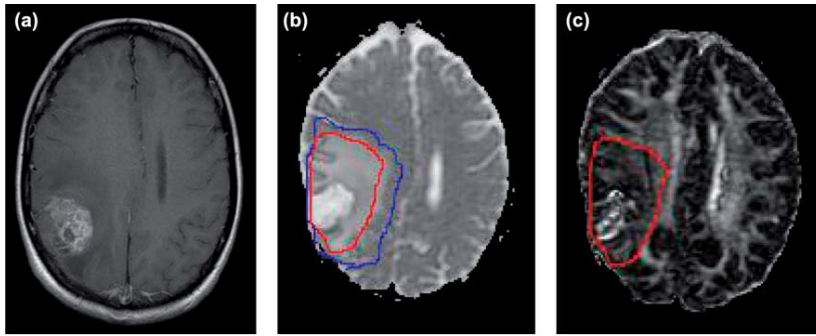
The method proposed by [Mohsen et al., 2013] consists of the analysis of the progression of glioblastoma (GBM) with diffusion tensor imaging (DTI). In this way it is possible to predict the tumour extension, using different patterns previously reported to correlate to histo-pathological evidence of the tumour infiltration. This image shows a case of Diffuse Invasive pattern. (a) Post-contrast T1-weighted image shows a GBM in the right parieto-occipital region, surrounded by necrotic zones. (b) p-component of the tensor information with the isotropic region of interest (ROI) (blue) and anisotropic ROI (red). (c) q-component of the tensor information showing the distorted white matter (WM) tract due to the presence of the gross tumour abnormality. Image courtesy of [Mohsen et al., 2013].
